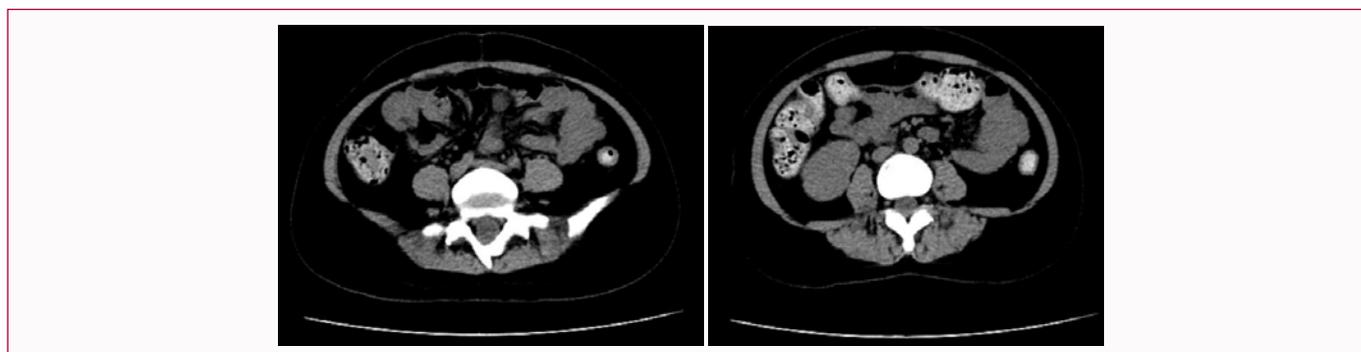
Abdominal computed tomography.
